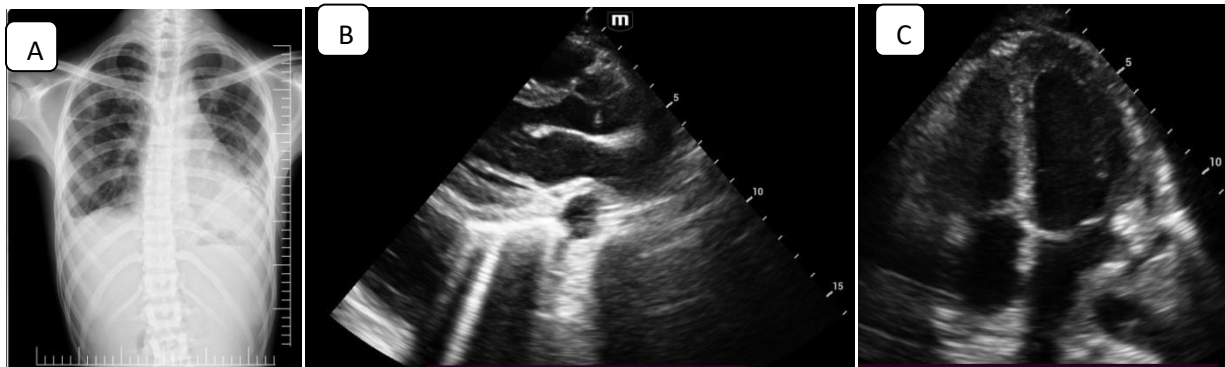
A: Discharge chest x-ray showing minimal pleural effusion. B & C: PSAX and APICAL 4 chamber view minimal pericardial effusion, respectively.
